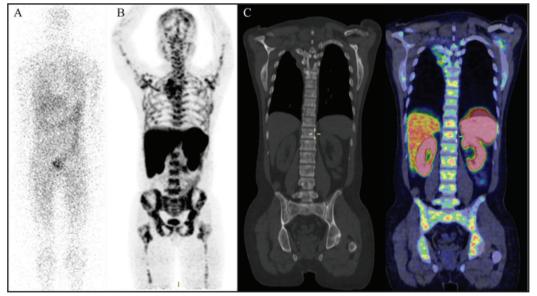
Comparative imaging evaluation of extent of disease of Patient 3 at initial diagnosis. Anterior planar image of staging ¹³¹I-MIBG scan (A), showing fewer lesions compared to maximal intensity projection image of ⁶⁸Ga-DOTATATE PET/CT (B); representative coronal ⁶⁸Ga-DOTATATE PET/CT images of tracer-avid bony lesions (C).
